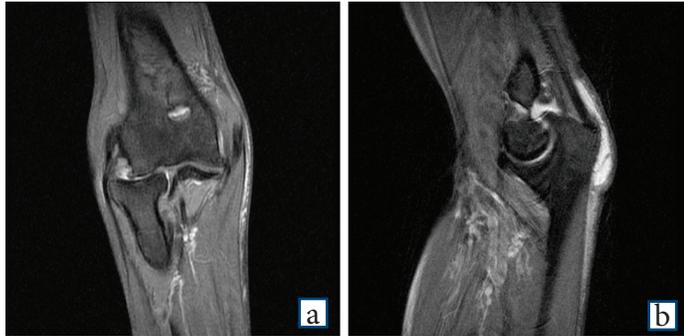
Left Elbow Cor PD FSat MR Left elbow MRI imaging shows olecranon bursitis
